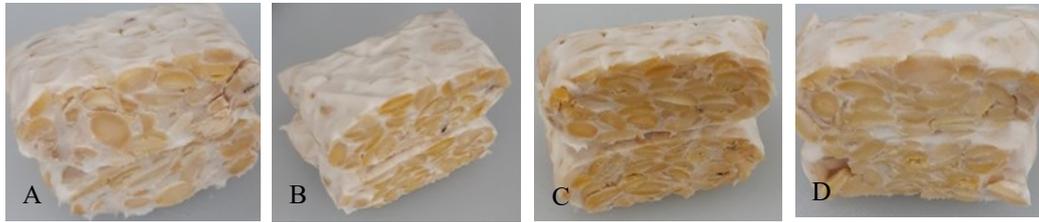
Appearance of (a) CT, (b) LF, (c) LFLP, (d) LP tempeh variants
